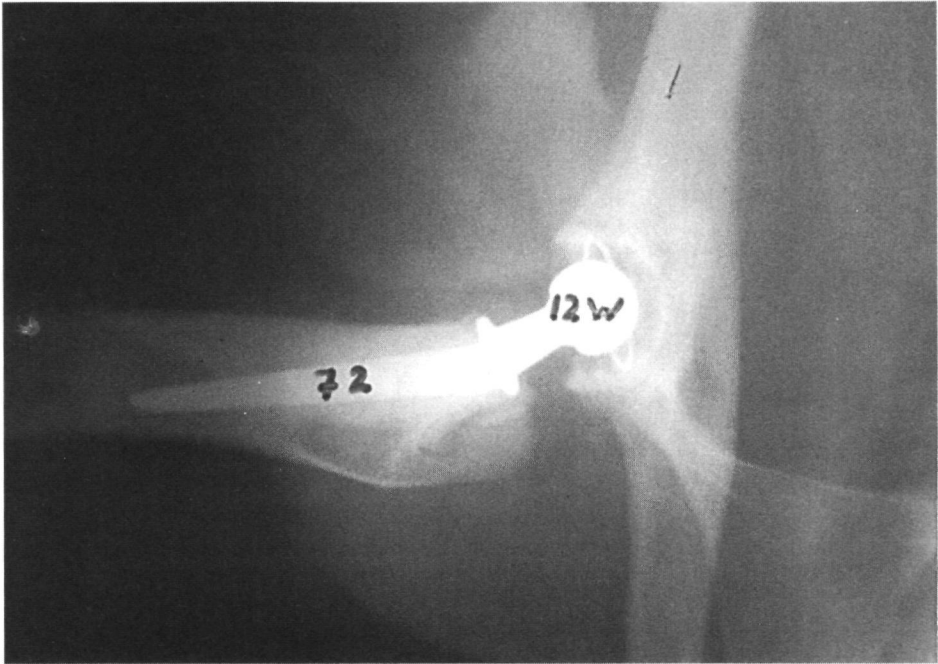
After 12 weeks the acetabular bone graft can not be distinguished anymore from the host bone bed and is considered radiographically incorporated*
